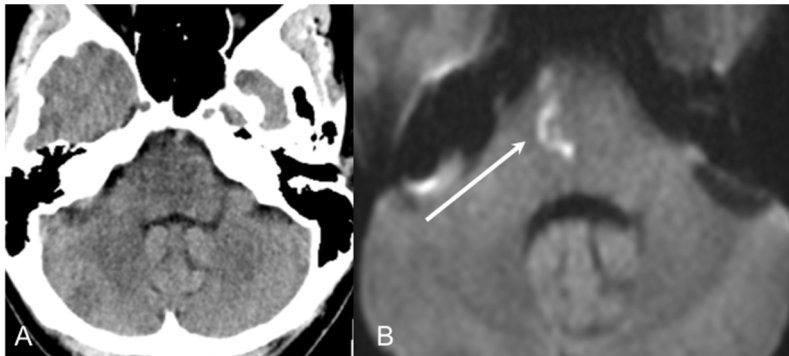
(A) CT and (B) MRI-DWI of acute ischemic stroke affecting the brainstem. The lesion is not detected on CT but is clearly visualized on MRI-DWI.
